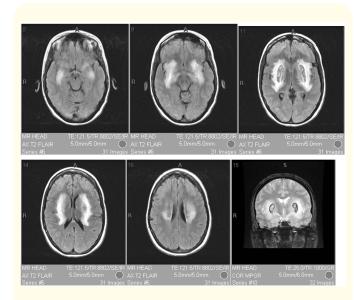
MRI images from the patient's case demonstrating significant bilateral signal alteration of areas including the basal ganglia, putamen, and caudate nuclei consistent with toxic methanol ingestion.
